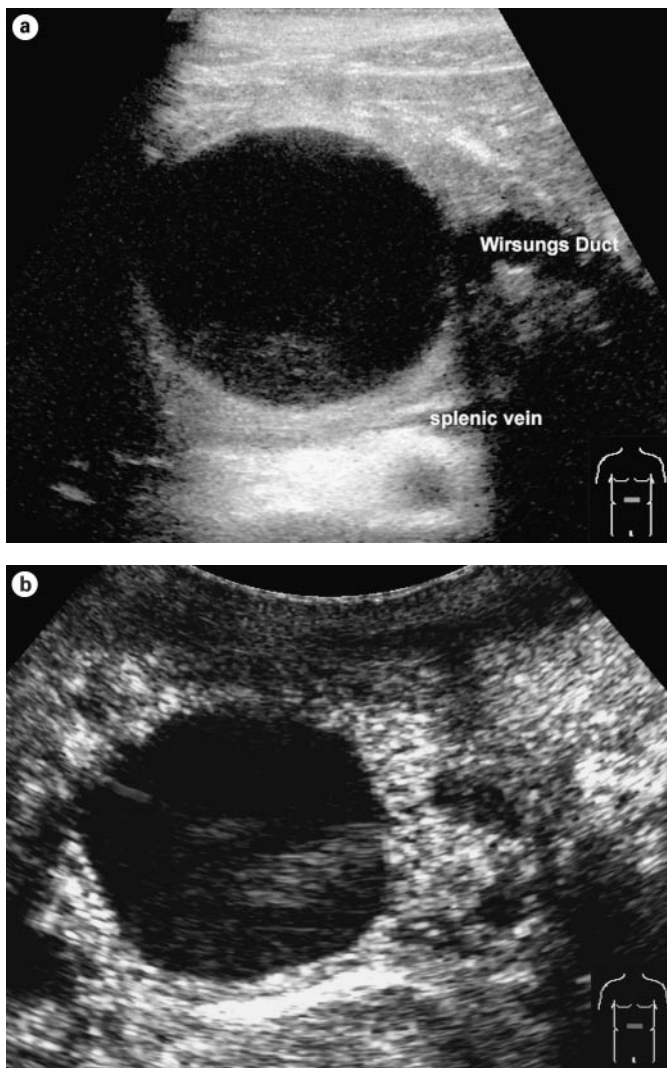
Pseudocyst at conventional (a) and echo-enhanced sonography (b). a Lesion with an echo-free pattern and a sharply delineated wall. Wirsung's duct is dilated. b Highly vascularized wall.
